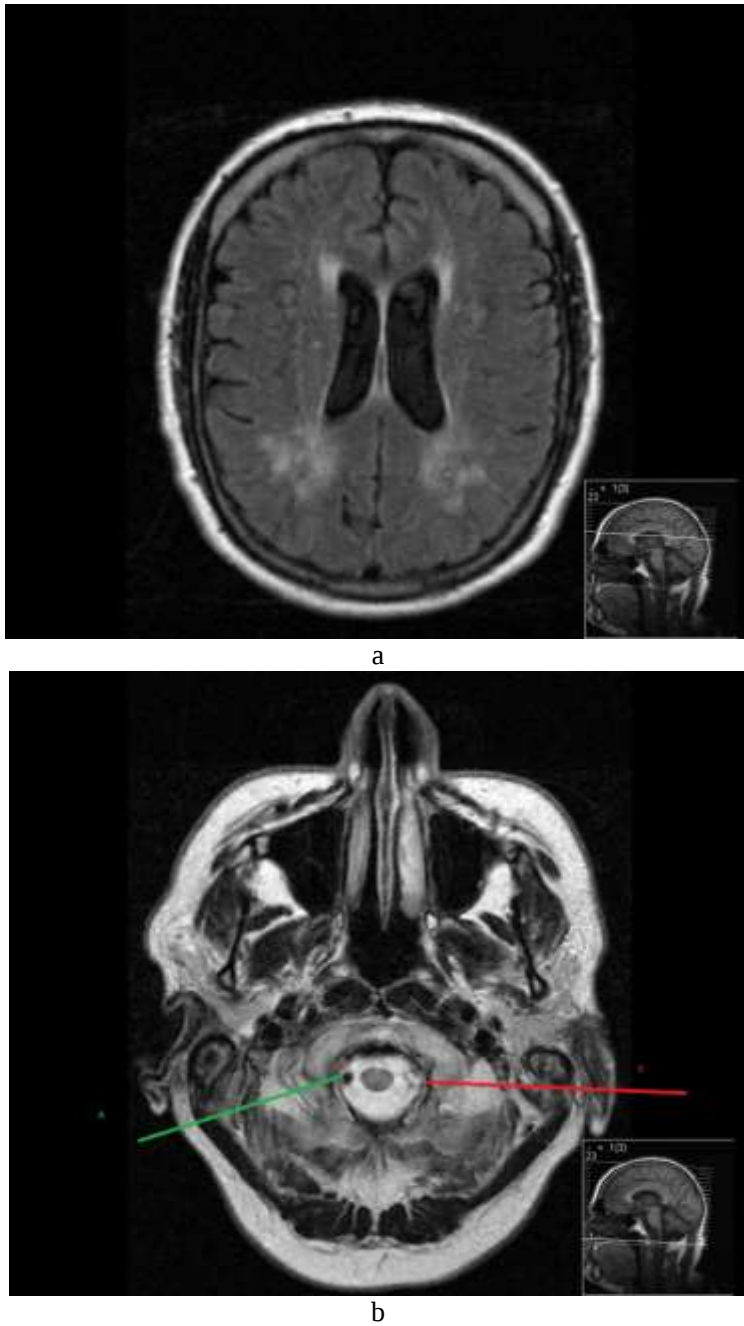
(a) MRI scan to show white matter lesions on FLAIR sequences. (b) There is marked asymmetry of the vertebral arteries and the distal left intracranial segment has a reduced lumen with reduced flow (see arrows); this is due to structural tortuosity of the artery, which is a frequent finding in Fabry disease.
